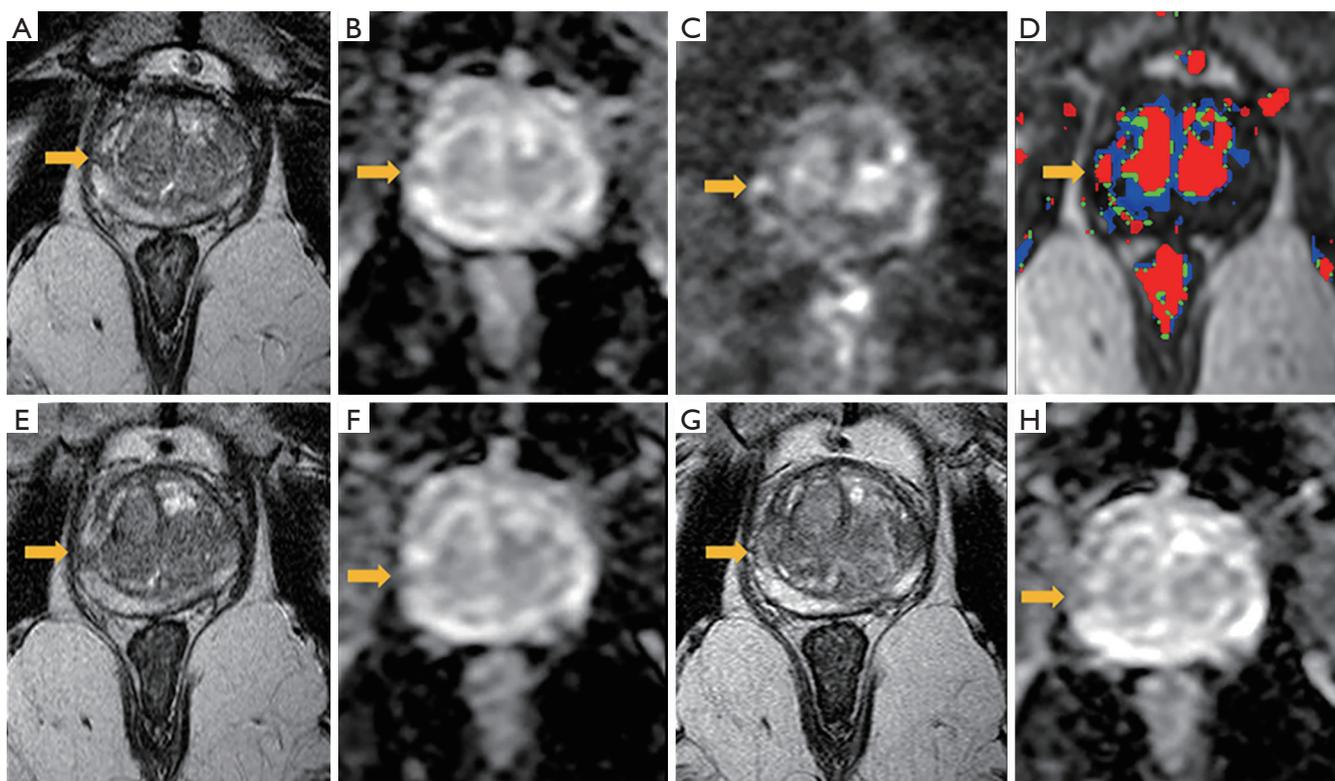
A 65-year-old male with a history of TRUS biopsy performed at another institution presents for repeat biopsy. Pathology from the TRUS biopsy showed atypical small acinar proliferation and the patient's PSA was 5.35ng/mL. Prior to the repeat biopsy, the patient underwent prostate mpMRI (A-D). A circumscribed, focal lesion in the right mid lateral peripheral zone (A) was identified with hypointensity on ADC (B) with associated hyperintensity on high b-value DWI (C). This lesion demonstrated associated abnormal perfusion (D) and was suspicious for csPCa. The patient underwent MR-US fusion biopsy with Gleason 3+3=6 disease on pathology and elected for AS. Subsequent mpMRI in one year demonstrated stability of this focal lesion on T2-weighted images (E) and ADC (F). The lesion remains stable at two-year follow up on T2-weighted images (G) and ADC (H).
